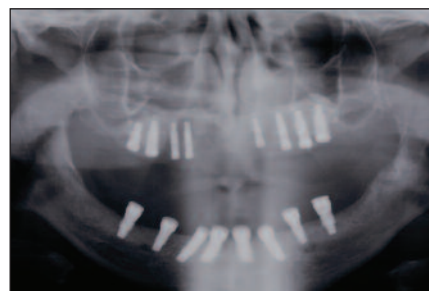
Panoramic radiograph with maxillary and mandibular implants in place.
